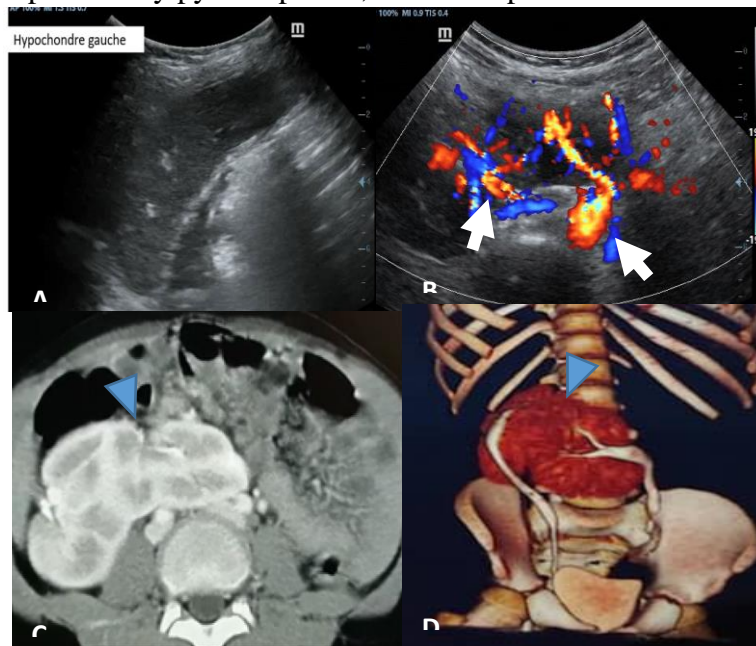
Ultrasound (A and B) and CT-scan (C and D) cross-sections and 3D VRT of urinary tract
